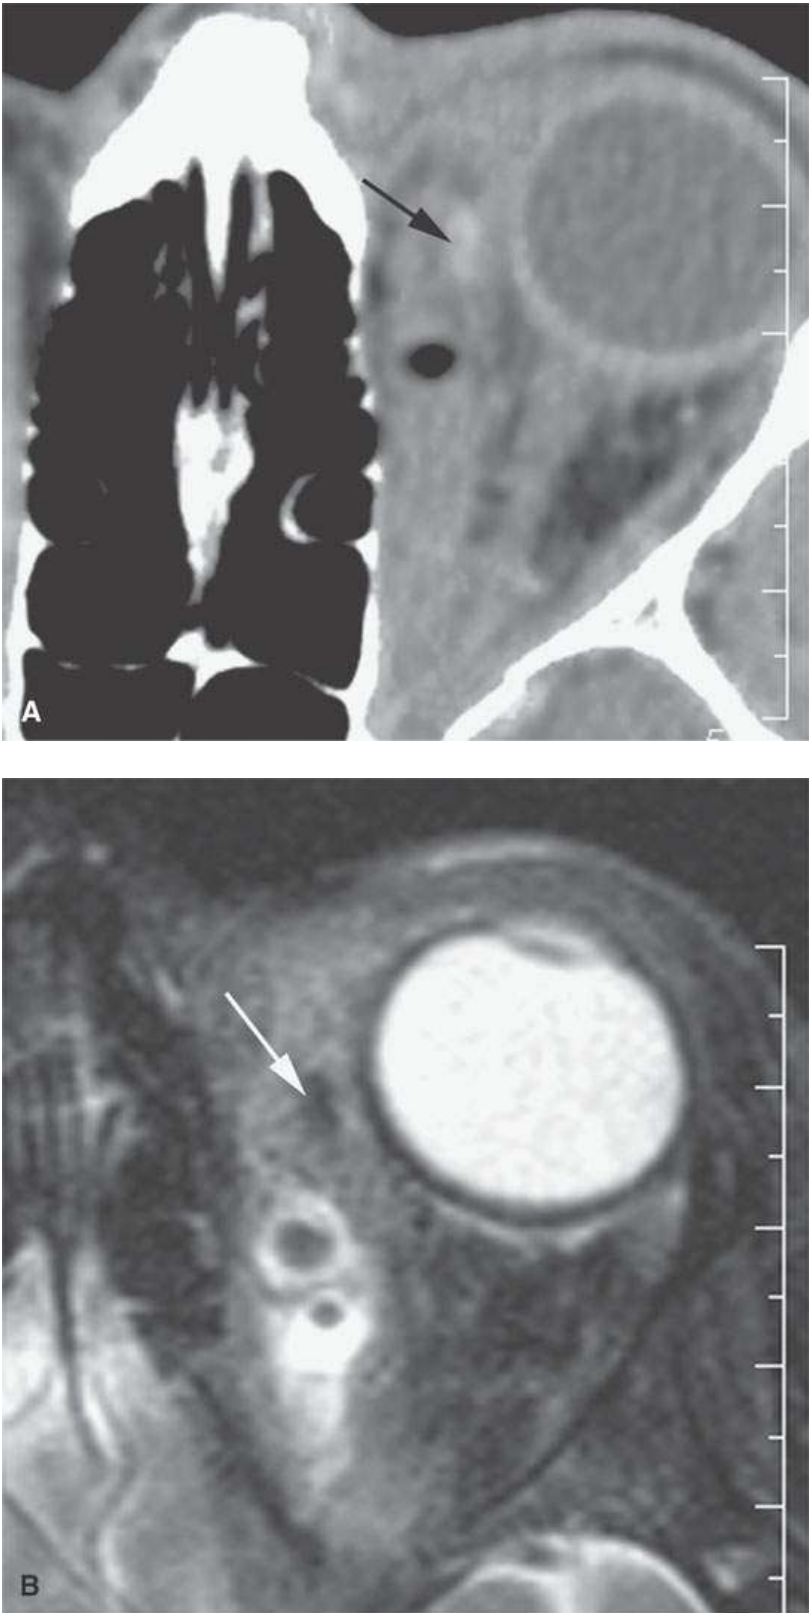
Penetrating orbital trauma. A:The wood fragment (*arrow*) is the same density as expected from calcification seen in the non-contrast-enhanced CT. Note the gas. B: In the T2-weighted magnetic resonance imaging, both the foreign body (*arrow*) and gas show as signal voids an obviously more ambiguous and less helpful scenario than with CT.
